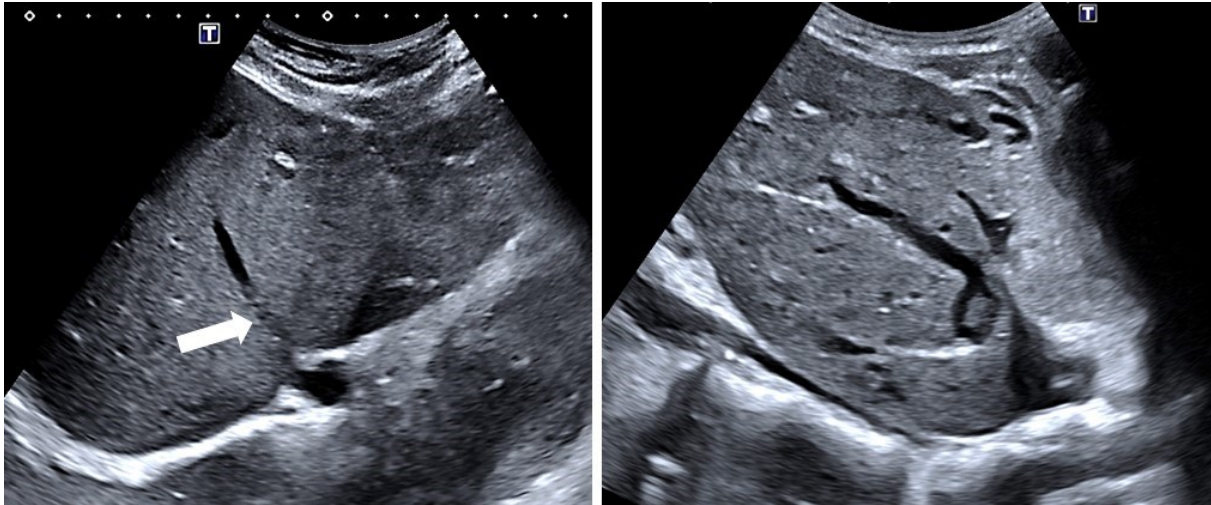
a.5. B-mode and Doppler images of Budd-Chiari syndrome. Segmental obstruction of the middle hepatic vein (white arrow, left panel); intrahepatic venous collateral resembling hockey-stick (right panel).
